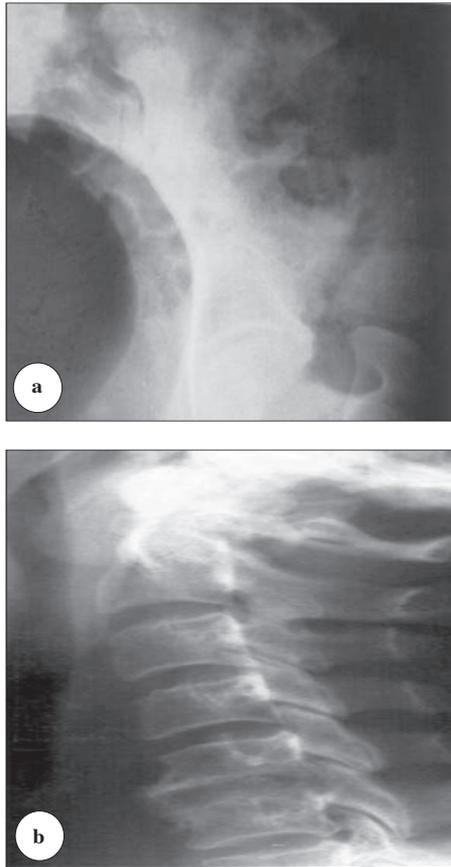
X-ray results of patient's one a) Anteroposterior radiograph of the left hip and pelvis showing fracture of anterior superior iliac spine after graft harvest for cervical spine fusion. b) Lateral radiograph of the cervical spine showing iliac crest bone graft in place between C5-C6 vertebrae.
